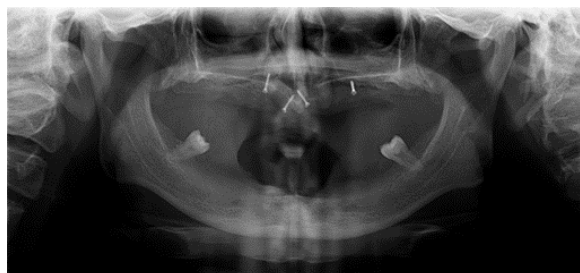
Pre-operative orthopantomogram showing maxillary augmentation with graft stabilizing pins and right and left mandibular third molars in an atrophic arch
